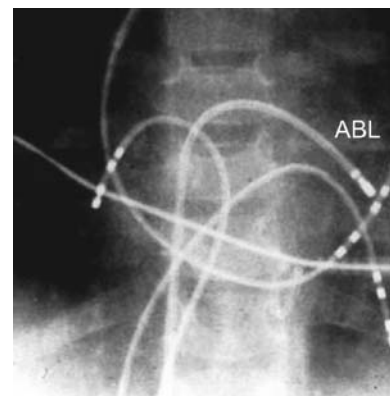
Mapping procedure using multiple catheters. This is an X-ray image of the heart showing the ablation catheter (ABL), and additional catheters for recording electrograms inside the heart. From the relationship between the electrograms at the different sites, the physician can determine the mechanism of the arrhythmia, and site of ablation. (Image provided courtesy of J. Phil Saul, Medical University of South Carolina.)
